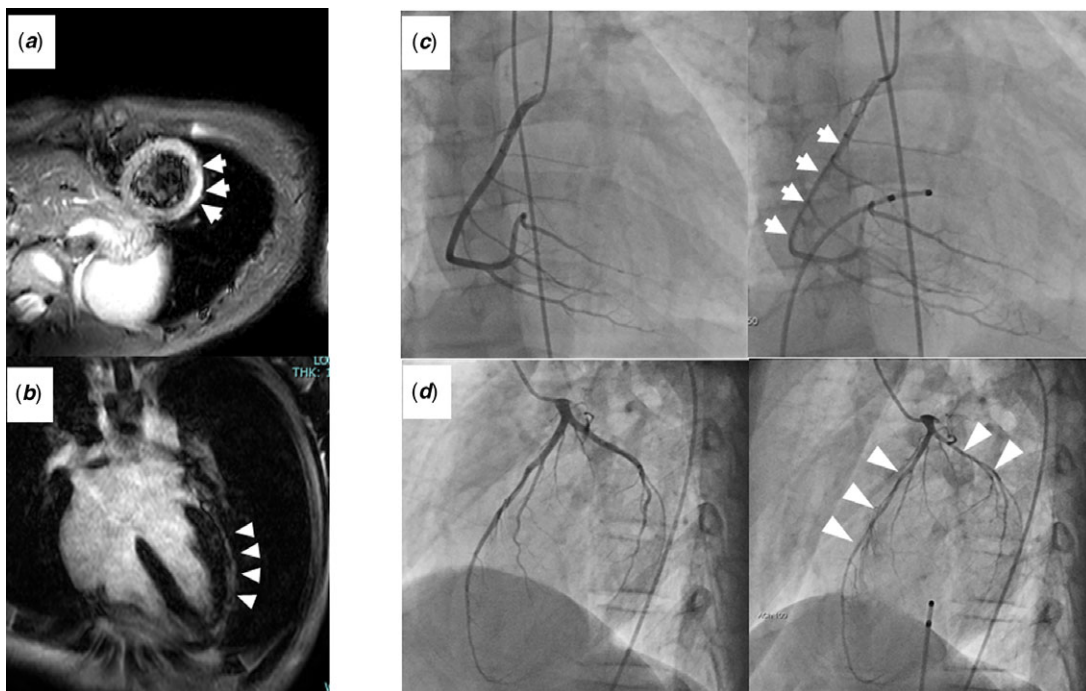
(a, b) Cardiac MRI showed positive late gadolinium enhancement. (white arrows and white arrow heads) (c) Right coronary angiogram (d) left coronary angiogram Achetilcholine provocation test demonstrated diffuse vasospasm of both coronary arteries. (white arrows and white arrow heads).
